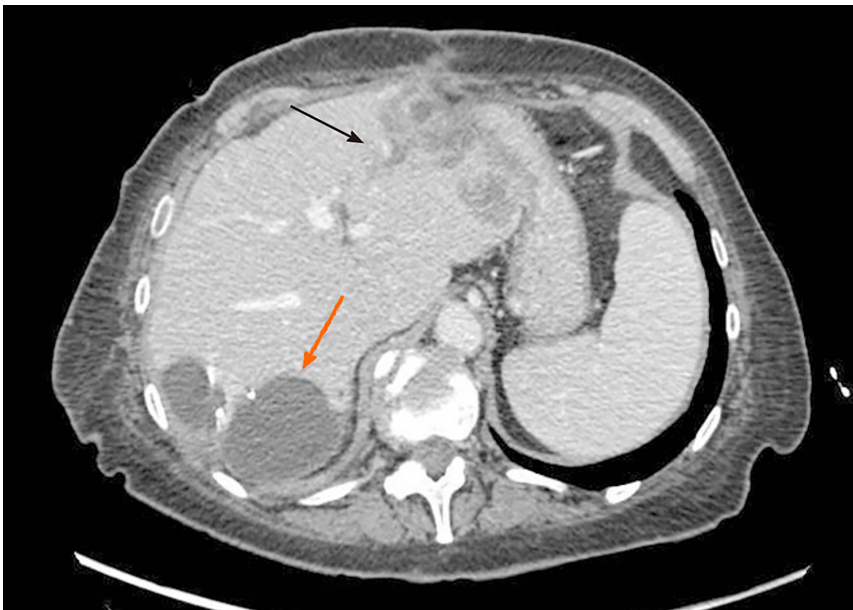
Computed tomography-scan performed one month after trans-arterial radioembolization. The reduction of the lesion of the left lobe and the intrabiliary growth pattern (black arrow). An intrabdominal fluid collection was found close to the surgical site (orange arrow).
